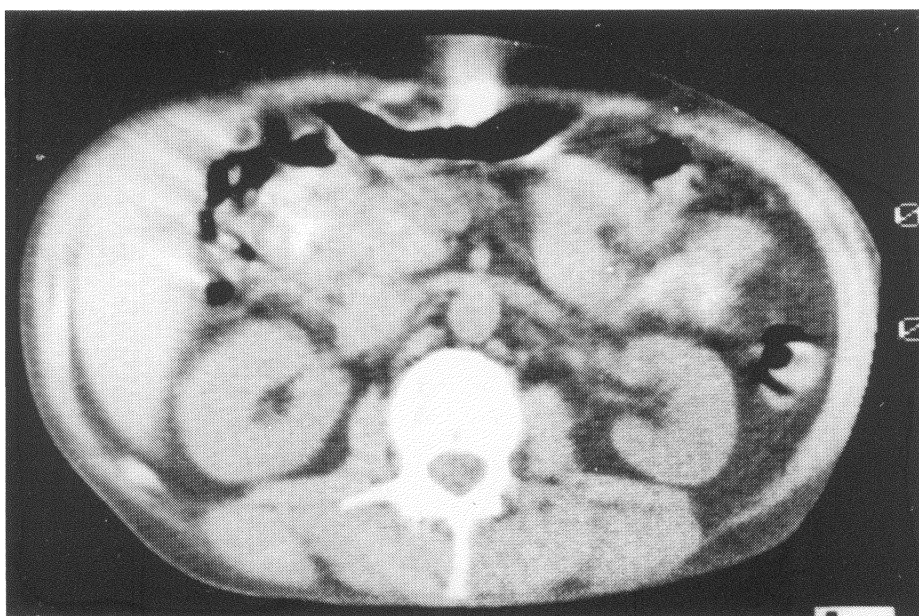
CT scan demonstrating a moderately large mass containing contrast medium in the region of the head of pancreas.
